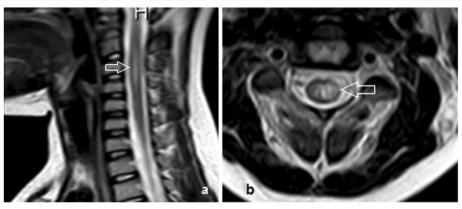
MRI demonstrates a sagittal and b axial cervical spine T2W image for a 5-year-old female showing a segment of signal alteration noted at the cervical spinal cord opposite C2, C3, and C4 levels eliciting bright T2 signal
